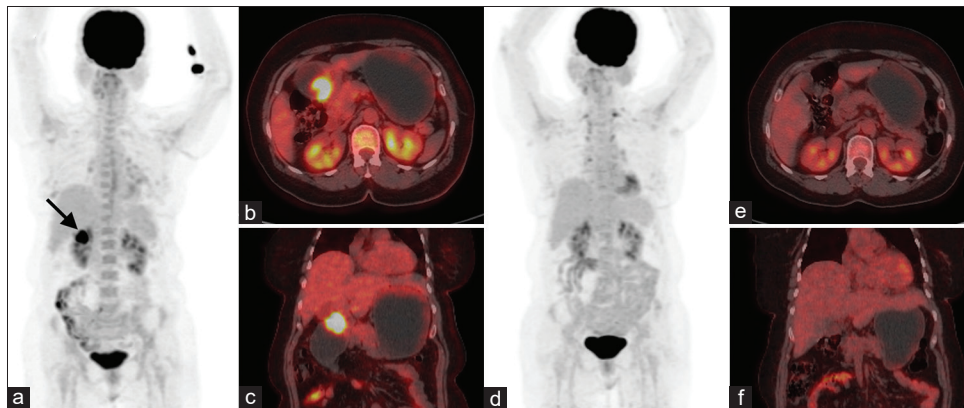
Case of 60-year-old female diagnosed with B-cell NHL. She underwent baseline Positron emission tomography/computed tomography (MIP [a], trans-axial Positron emission tomography/computed tomography [b], coronal Positron emission tomography/computed tomography [c]), which revealed intensely 18F-FDG-avid thickening in the pyloric region. She underwent follow-up positron emission tomography/computed tomography for response assessment after 3 months (MIP [d], transaxial positron emission tomography/computed tomography [e], coronal Positron emission tomography/computed tomography [f]), which showed complete metabolic response
